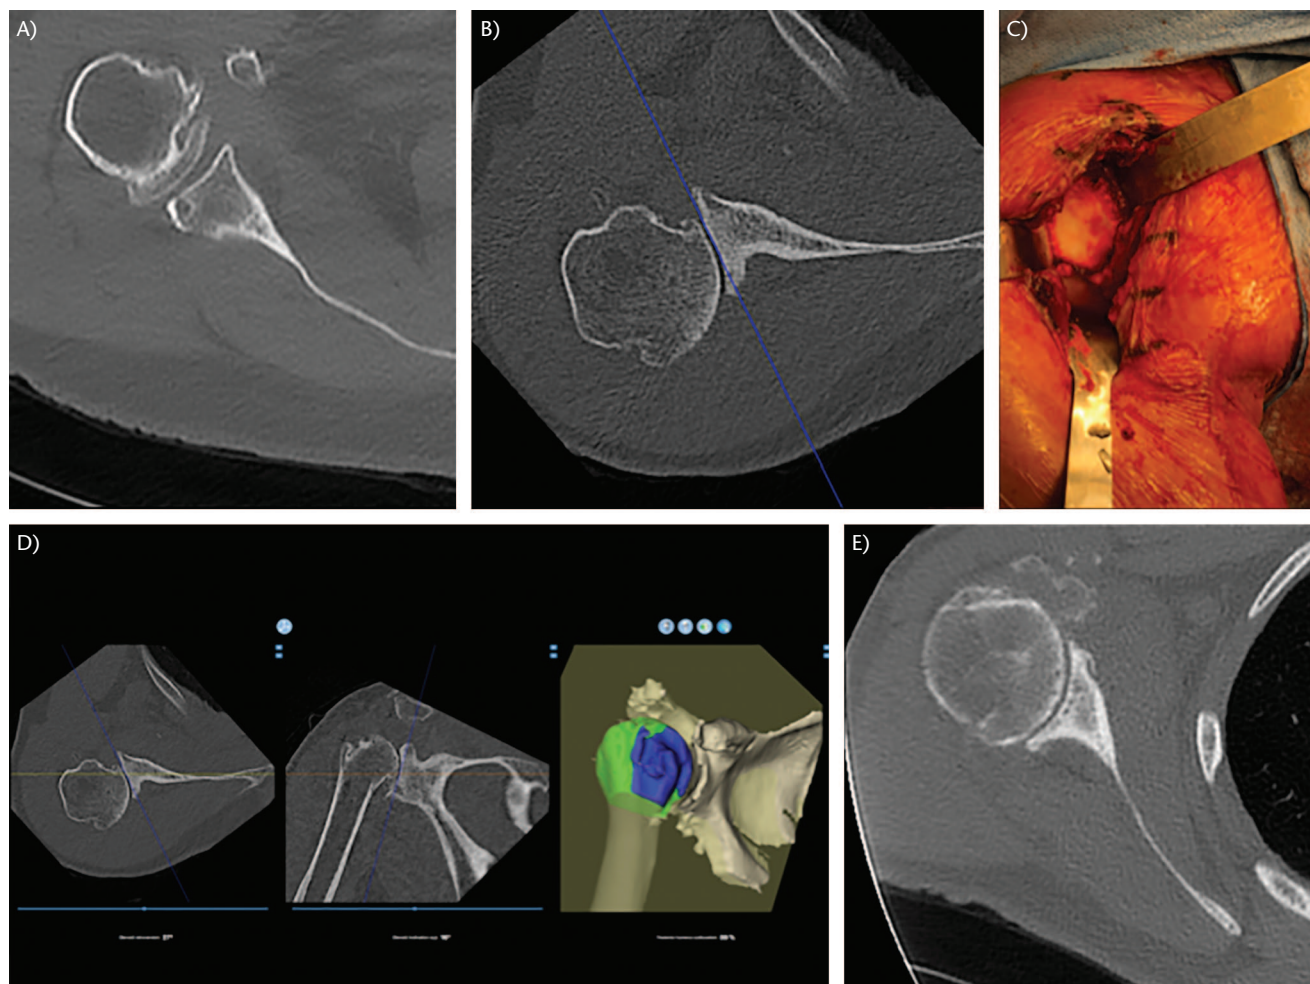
(A) Type B1 glenoid on axial CT, characterized by posterior glenoid wear without significant glenoid erosion; note the subchondral cyst beneath the posterior glenoid articular surface. (B) Type B2 glenoid on axial CT, characterized by posterior subluxation of the humeral head on the glenoid, with subsequent posterior glenoid erosion and a characteristic biconcave appearance. (C) In vivo B2 glenoid during a right shoulder arthroplasty, with characteristic biconcave appearance with increased wear and sclerosis on posterior aspect of glenoid (left side of picture). (D) Type B2 glenoid uploaded into preoperative planning software, showing calculated glenoid version, glenoid inclination, and posterior humeral head subluxation measurements, respectively (BLUEPRINT, Wright Medical, Memphis, TN, USA). (E) Type B3 glenoid on axial CT, characterized by progression of posterior wear leading to an excessively retroverted, monoconcave glenoid.
